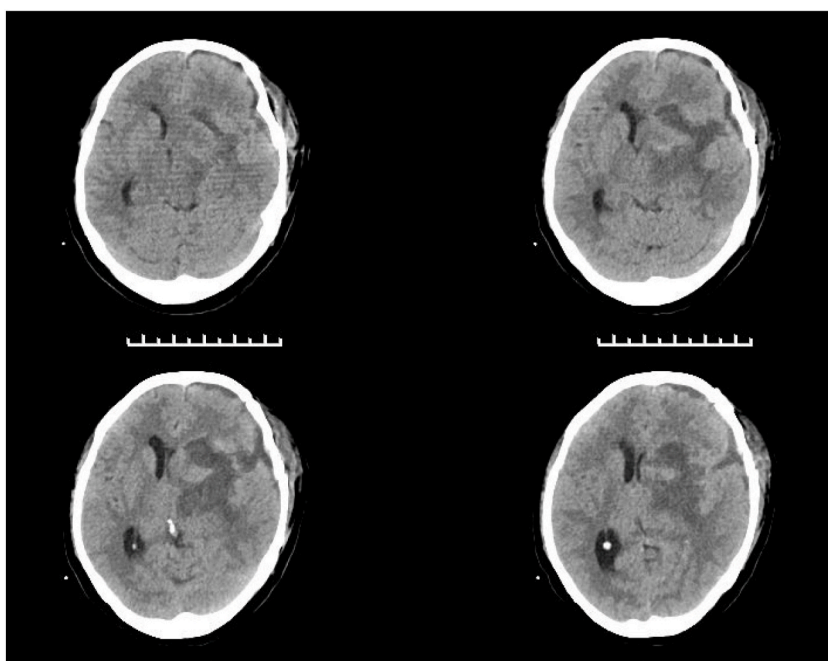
CT head examination was performed on the 19th day after operation.
